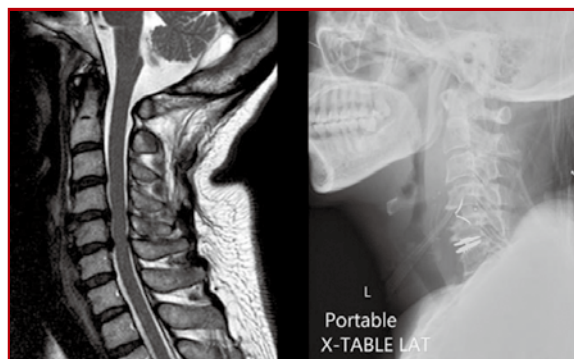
A 62-year-old woman presented bilateral radiculopathy with pain and numbness. MRI (left) showed C4-6 spondylosis. Hybrid ACDF with ADR was performed (right). (Personal collection)
